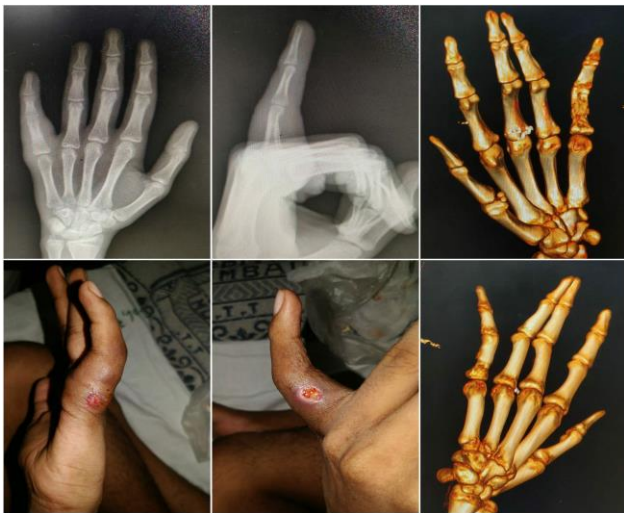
Clinical pictures and X-rays at 3 weeks post-operative.
